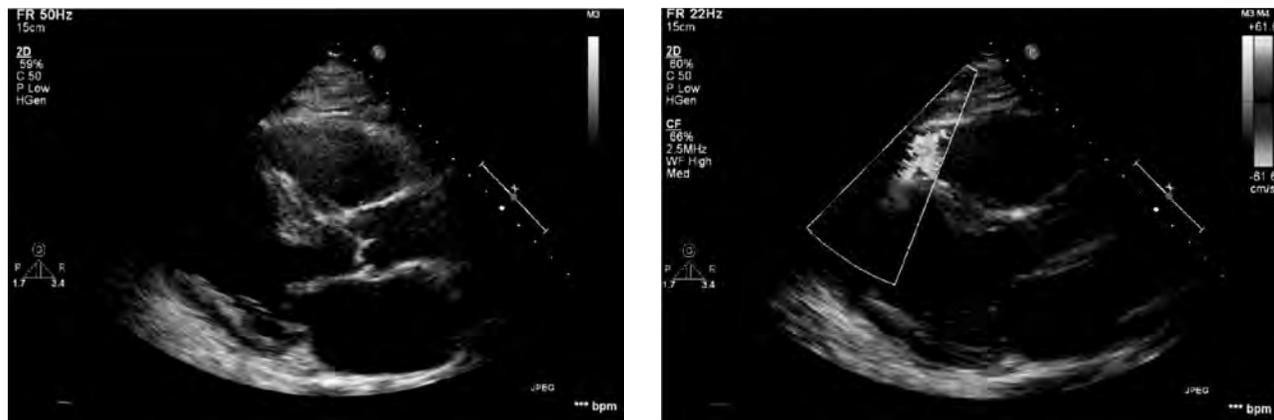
Ventricular septal defect and shunt from the left to the right (a parasternal long-axis view)
